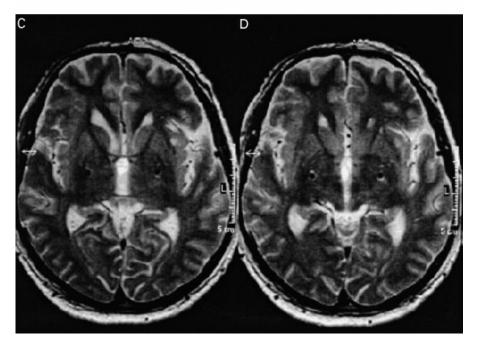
Axial MRI sections of 3 mm thickness (0 mm between sections) presented rostrocaudally $(\mathbf{A}-\mathbf{D})$ in Case 14, with cervical dystonia. Contacts 01 are in the region of GPi (\mathbf{C}, \mathbf{D}) whereas contacts 23 are in the region of GPe (\mathbf{A}, \mathbf{B}) bilaterally. The macroelectrode tip was visualized in the section below D (not shown).
